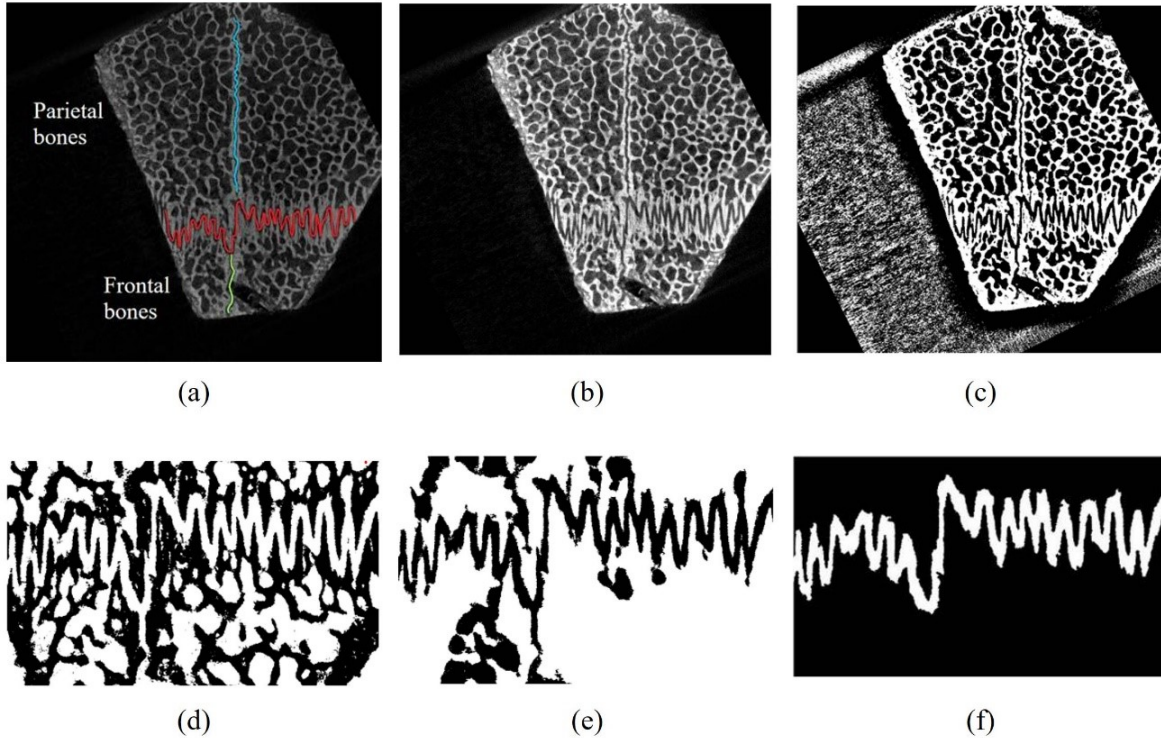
Image processing of coronal suture, (a)-(c) show the entire sample, (d)-(f) show the cropped area; (a) Raw reconstructed μ CT image, sagittal suture shown in blue, coronal in red, and interfrontal in green; (b) Contrast adjusted image; (c) Binarized image; (d) Cropped binarized image; (e) Area filtered image; (f) Final processed and segmented coronal suture
